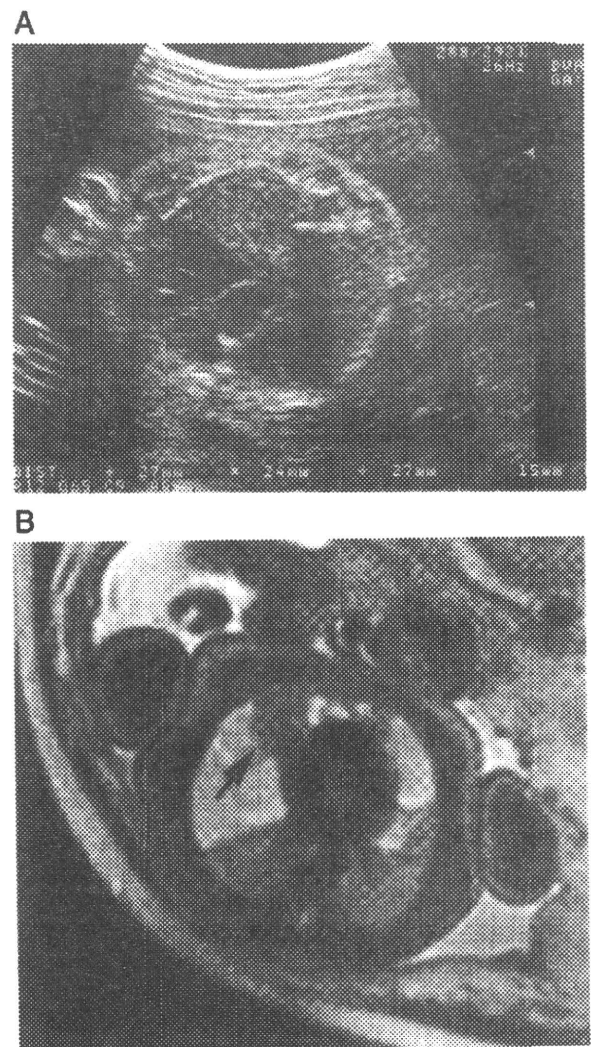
A, Fetal ultrasound performed 3 days after the aspiration of the tumor cyst fluid. The cystic lesion decreased in size dramatically and the size of the lung increased. B, Fetal magnetic resonance imaging (single-shot turbo spin echo sequence: repetition time, 900 milliseconds; echo time, 84 milliseconds) obtained in an axial plane at 36 weeks of gestation (after thoracocentesis). The solid component of the tumor increased in size (arrow in A).
